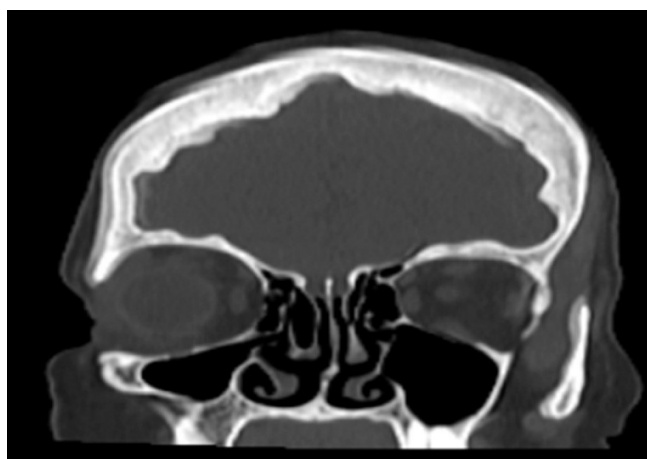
CT scan image of maxillary sinus axial view
